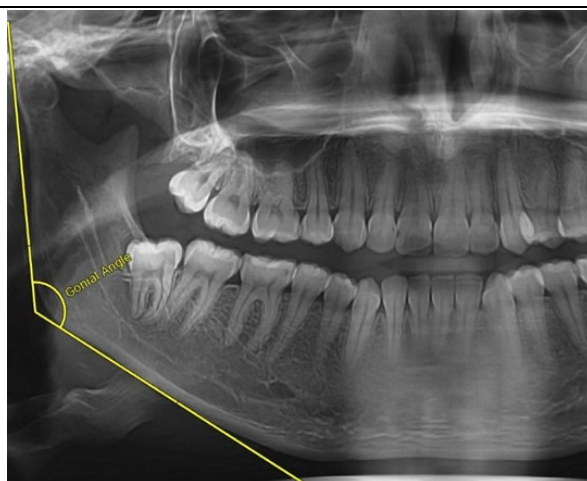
Measurement of the gonial angle in a Lateral Cephalometric radiograph
